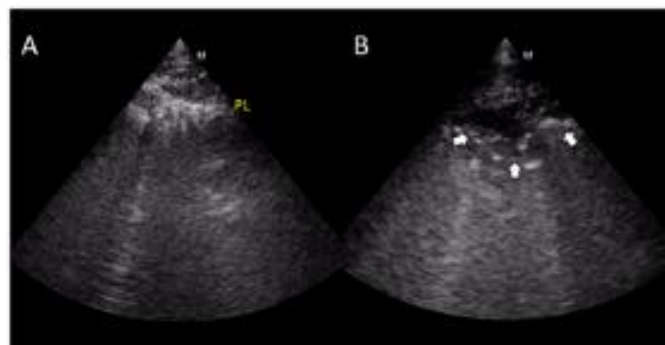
An ultrasound of the lungs that shows signs leading to a diagnosis of non-cardiogenic pulmonary edema. A. Thickened and irregular pleural line. B. Subpleural (arrow) consolidation (Santangelo et al., 2023).
